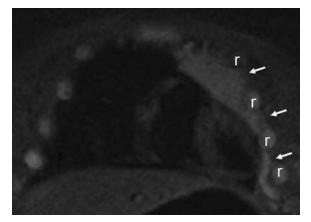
Coronal MRI of the chest (short tau inversion recovery [STIR] sequence) demonstrates a left-sided normal thymus in a 7-month-old infant. An anterior cut shows the "wavy thymus sign" *(arrows)* as the thymus insinuates itself between the anterior ribs (r).
